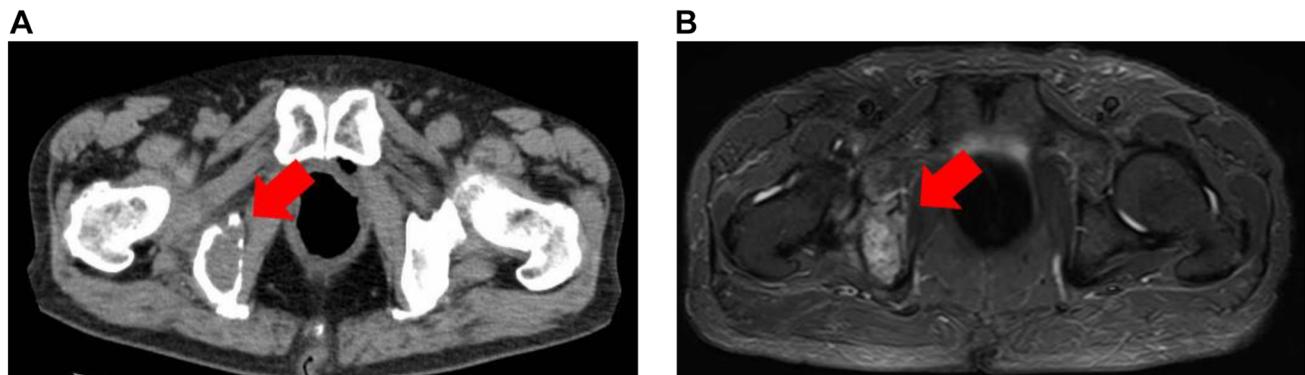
Plain computed tomography (A) and T1-weighted magnetic resonance imaging (B) showing a right ischial metastasis.
